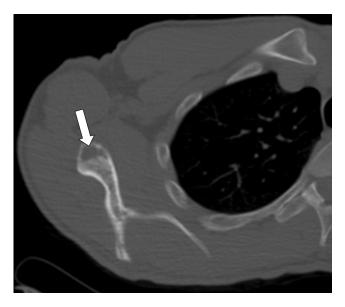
Selected transverse computed tomography images demonstrate aggressive lytic lesions of the sternum (arrow, upper panel) and the right scapular glenoid (arrow, lower panel).
